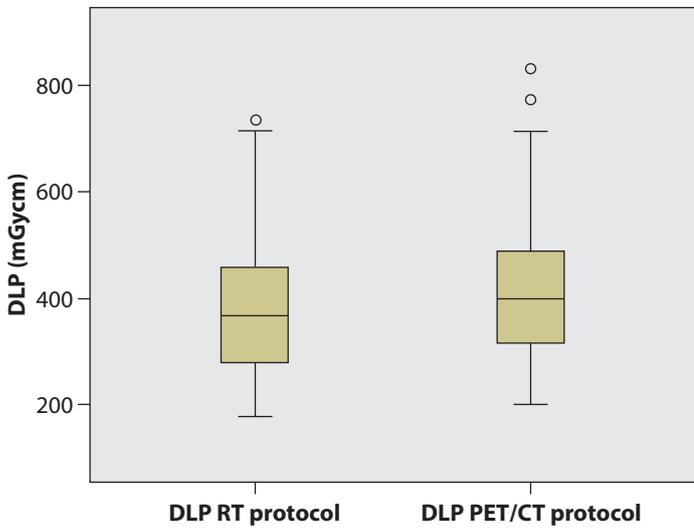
Comparison of the DLP of the radiotherapy (RT) and standard PET/CT protocols
